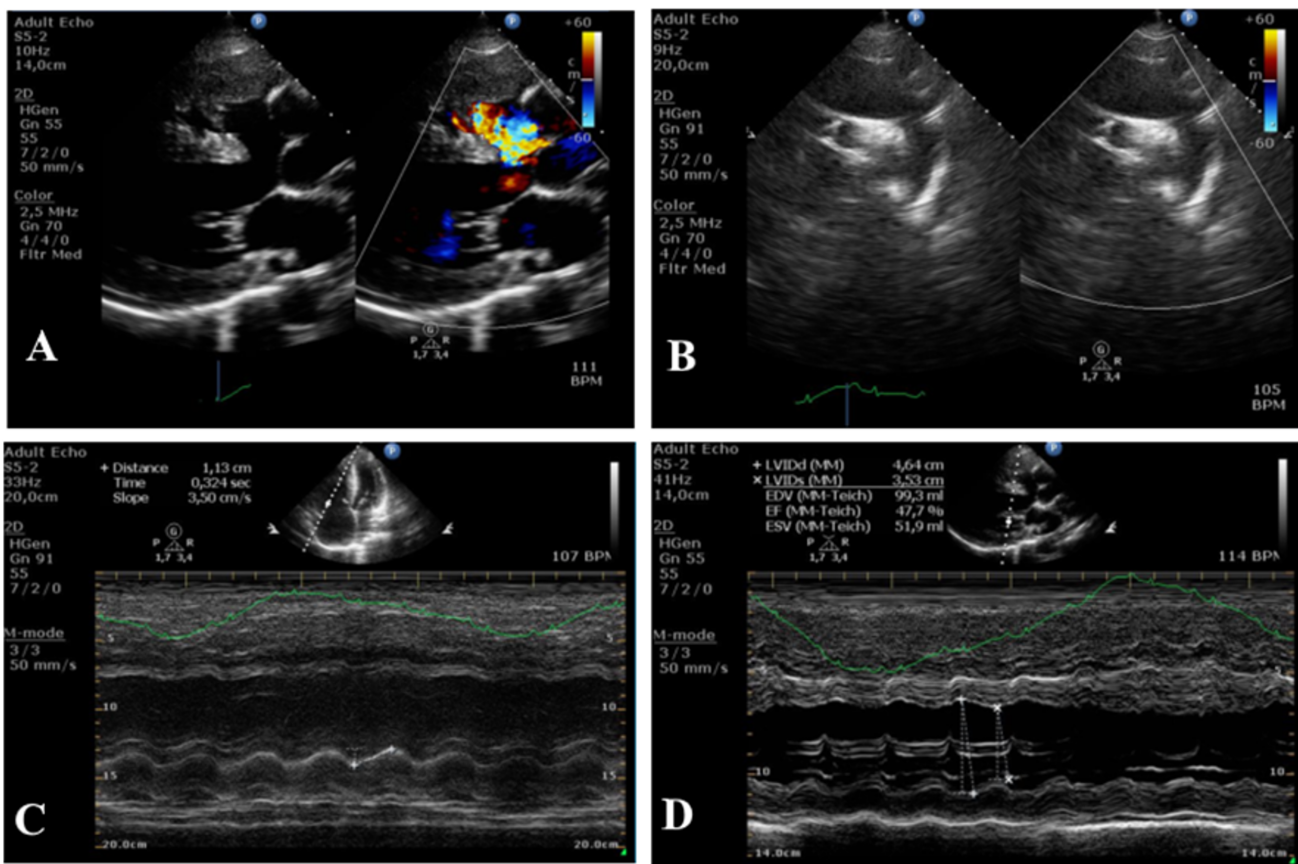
(A). Echocardiography 2D before BPV showed 50% Overriding aorta accompanied by anterocephalad deviated septum which caused (B) severe valvular pulmonary stenosis (PS), subaortic VSD with diameter 21 mm, L to R shunt (C) reduced LV systolic function (LVEF 71%), (D). dilated and right ventricular hypertrophy with reduced RV systolic function (TAPSE 18 mm).
